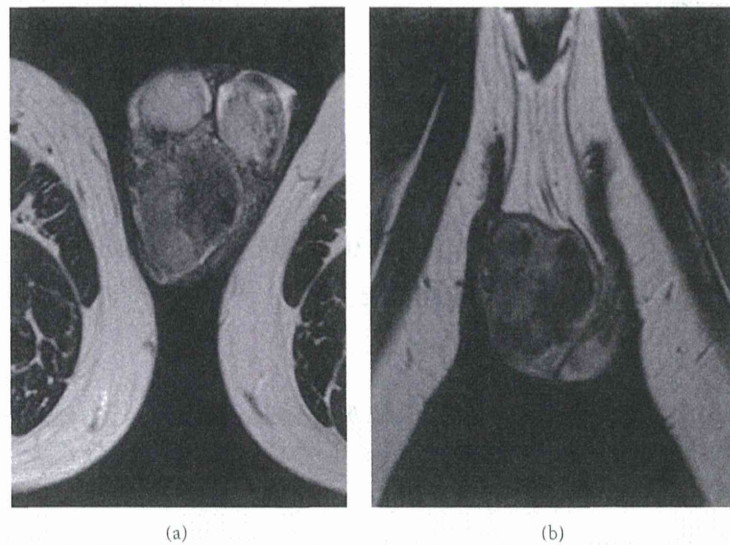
MRI T2 transverse (a) and coronal (b) images show a mass in the right paratesticular region.
